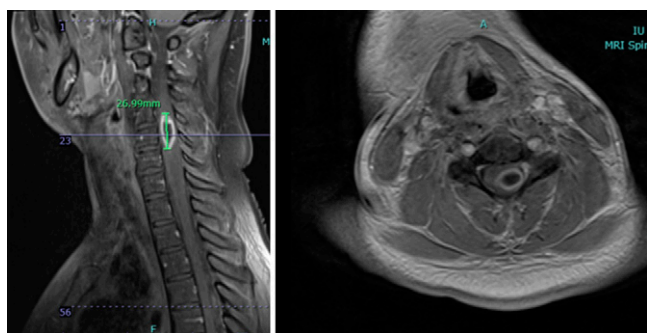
Sagittal (left) and axial (right) postcontrast T1-weighted MRI sequences demonstrating the cervical abscess. The axial section was selected at the level where an ultrasound-guided needle was placed orthogonally through the dura into the abscess.
